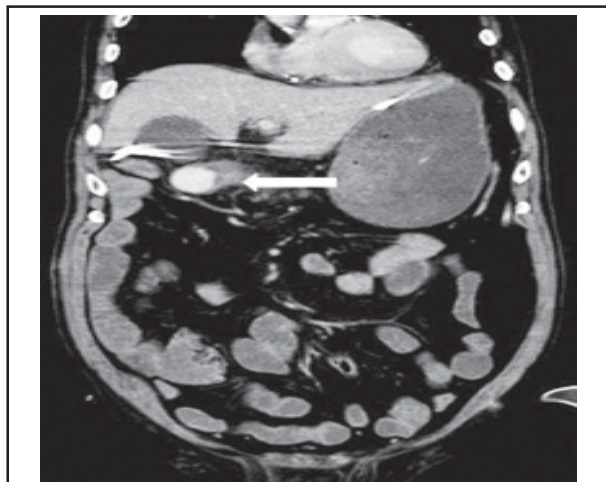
CTA showed a contrast extravasation lesion about 2.4 x 1.1 cm in duodenal bulb, consisted with aneurysm.
